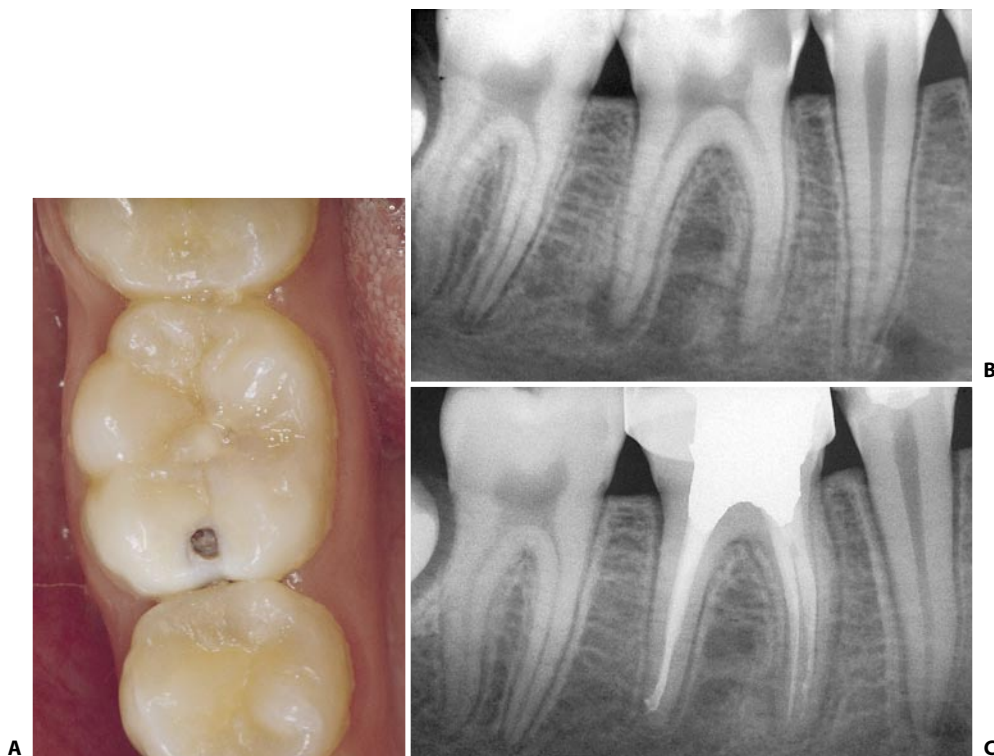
A. Occlusal surface of the asymptomatic lower right first molar with "small" interproximal caries in a 16-year-old patient. B. Radiographic appearance of the same molar. Note the extent of the penetrating caries, the widening of the periodontal ligament space on the distal aspect of the mesial root, and the radiolucency at the apex of the distal root. The root responds normally to all the pulp vitality tests, including the cavity test. C. Eight months later. Note the normal appearance of the lamina dura around the radicular apices.
